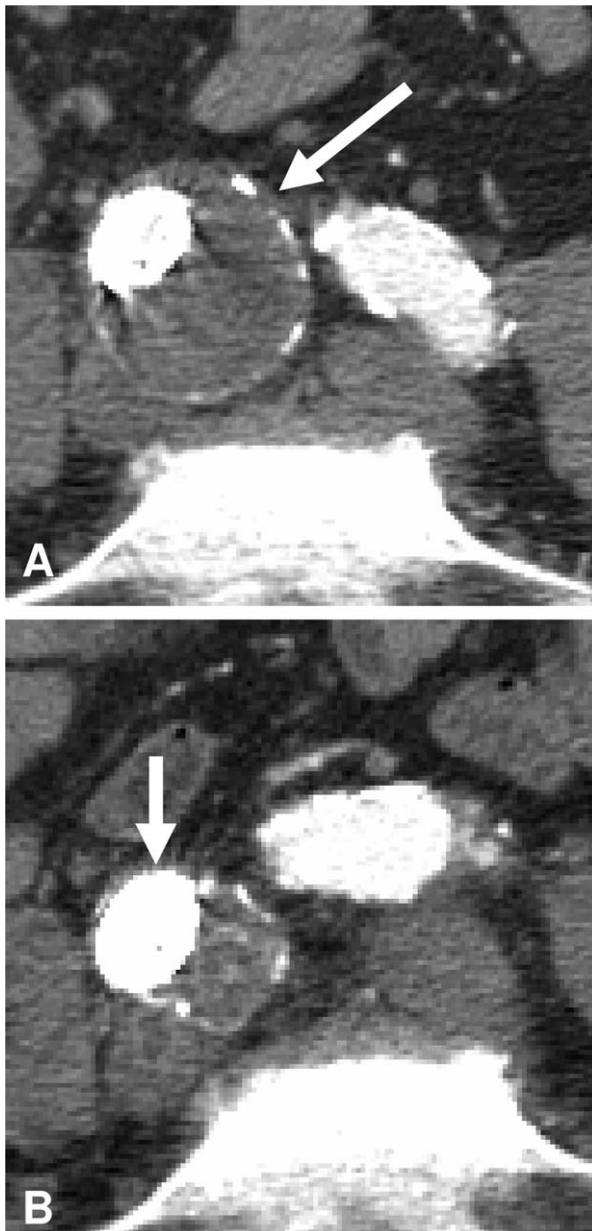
A 69-year-old patient with right common iliac artery aneurysm initially measuring 5.0 cm underwent endovascular repair. A, A computed tomography angiogram 1 month postoperatively shows the right common iliac artery aneurysm diameter has decreased to 4.2 cm (arrow). B, By 3 years, the aneurysm measures only 2.4-cm (arrow).
